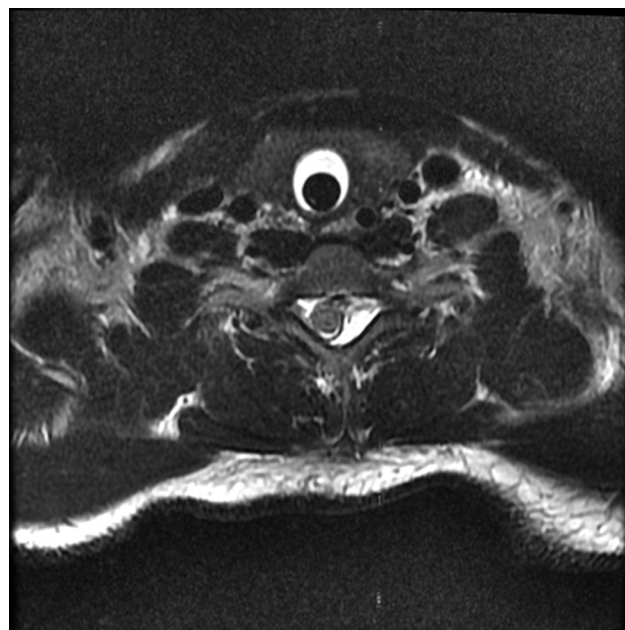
Axial T2-fast relaxation fast spin echo magnetic resonance imaging sequence at the C6–C7 level showing right-sided shift of the spinal cord.
